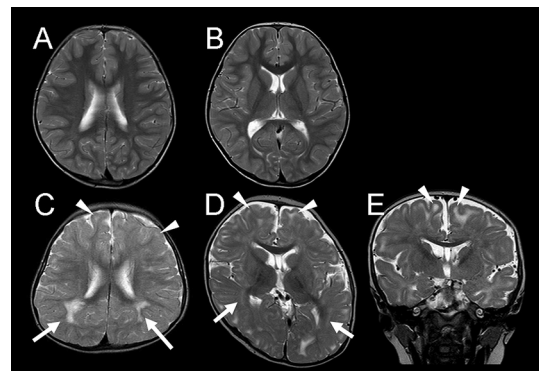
Brain MRI findings of the patients reported in this study. (A and B) The T2-weighted axial images of a normally developing 4-year-old boy, who was examined for the aim of the disease screening for epilepsy, with normal MRI results. (C) The T2-weighted axial image of patient 1 examined at 3 years and 8 months of age. (D, E) The T2-weighted axial (D) and coronal (E) images of patient 2 examined at 20 months of age. Compared to the normal control (A, B), both patients show T2-high intensities in their deep (arrows) and subcortical (arrow heads) white matter.
